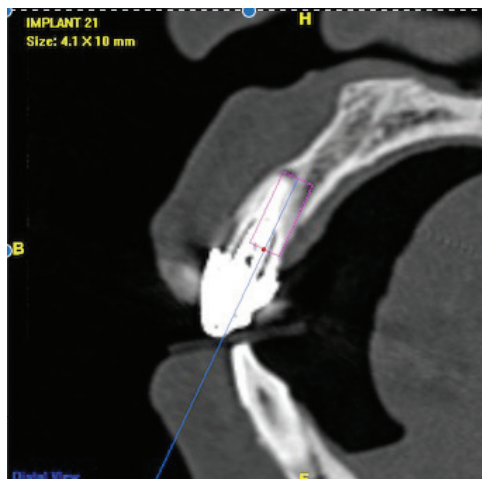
CBCT analysis of maxillary left central incisor
